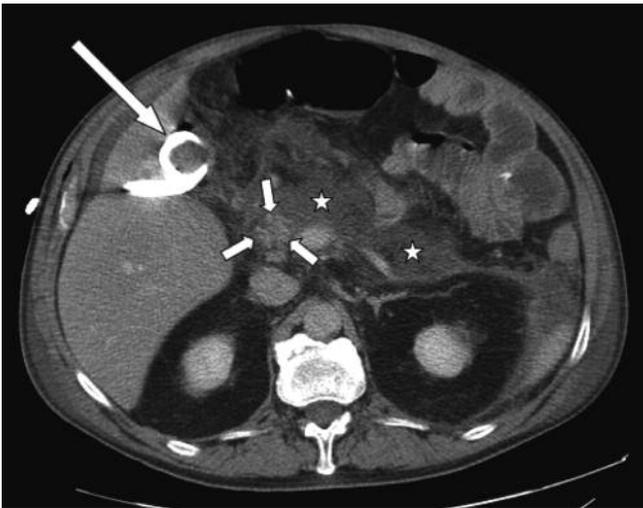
CT slice of the pancreas necrosis (stars) with the head remaining partially vascularized (short arrows). The long arrow points to the cholecystostomy.
